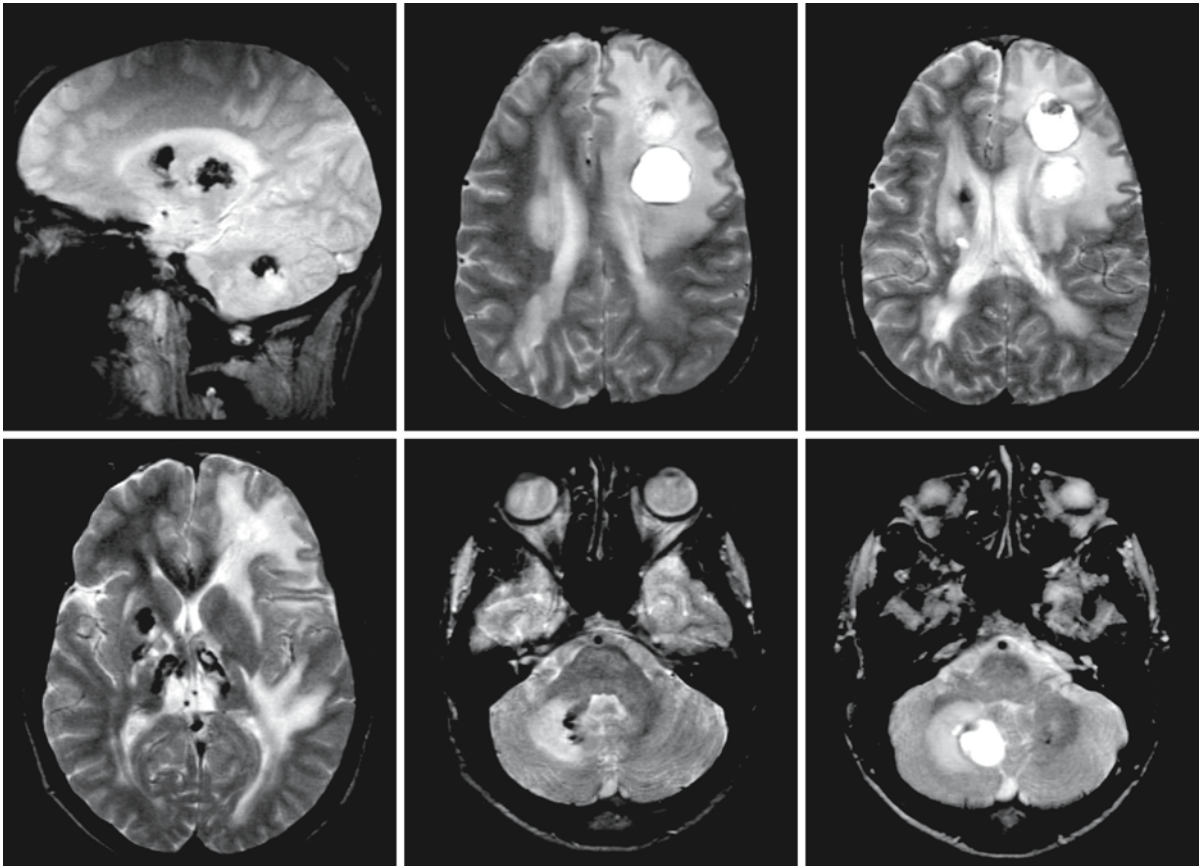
A boy with LCC syndrome started to have increasing walking difficulties at the age of 9–10 years. The first MRI was obtained at the age of 10 years. Note the calcium deposits in the basal ganglia, thalami, dentate nuclei, and lining of the cysts in the deep frontal white matter on the left and the cerebellum on the right, indicated by a low signal intensity on the gradient-echo (first row, left) and T₂-weighted images.
